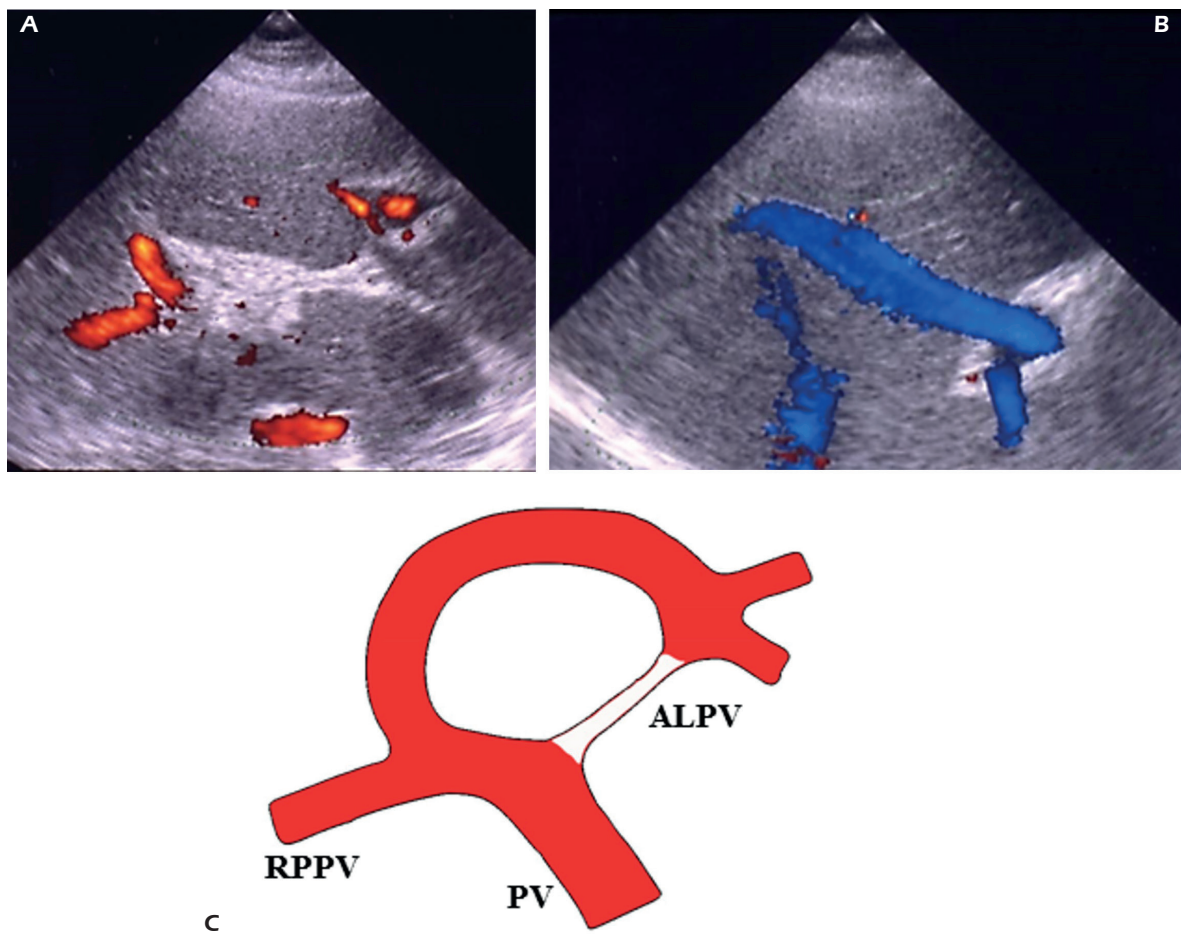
Portal vein variants – type 4: absence of portal vein bifurcation. *A*, Color Doppler sonography shows absence of portal vein bifurcation. *B*, Color Doppler shows a large vein coming from segment VIII and entering the distal segment of the left portal vein. *C*, PV: portal vein; RPPV: right posterior portal vein; ALPV: absent left portal vein.
